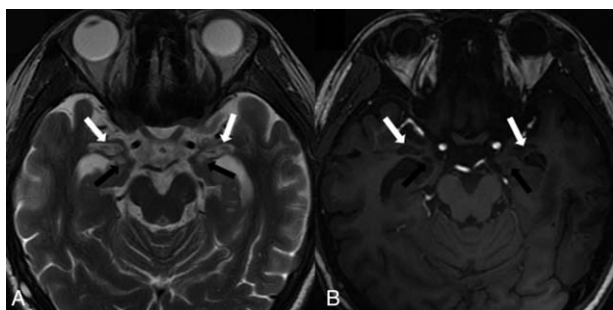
(A) T2-weighted MRI 6 months after the second surgery. (B) T1-weighted MRI 6 months after the second surgery. Black arrows indicate lesions produced by the first surgery. White arrows indicate lesions produced by the second surgery.
